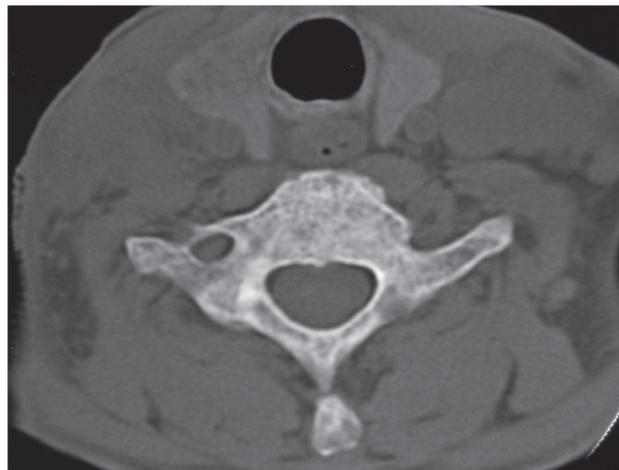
A 37-year-old male patient with primary spinal non-Hodgkin lymphoma. Axial CT shows the osteosclerotic (ivory) appearance of C7 vertebra.
